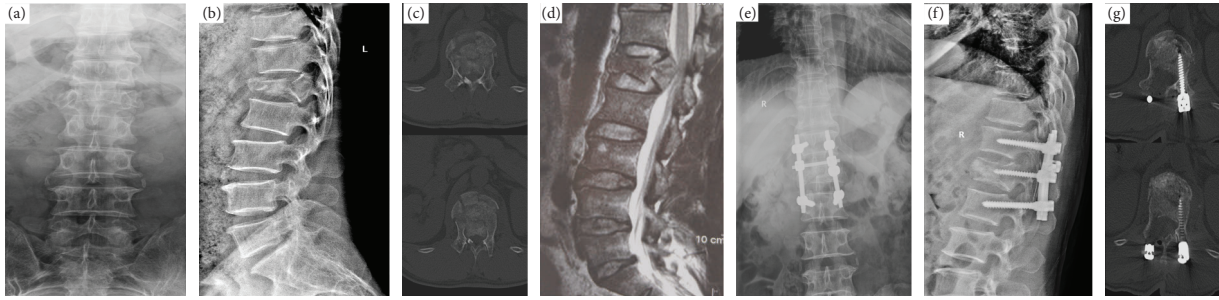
A 42-year-old male patient who was suffering from severe neurological deficit with a grade of ASIA B on admission. Preoperative X-ray (a, b) show L1 fracture with Cobb angle 22°, CT (c) with severe spinal canal encroachment, MRI (d) showed that the spinal cord was not transection in the injury segment. Undergoing simple posterior decompression fixation, patient achieved to correct segmental kyphosis deformity, restore vertebral body height (e, f), direct good decompress the neural elements (g) and neurological function improved to ASIA D.
